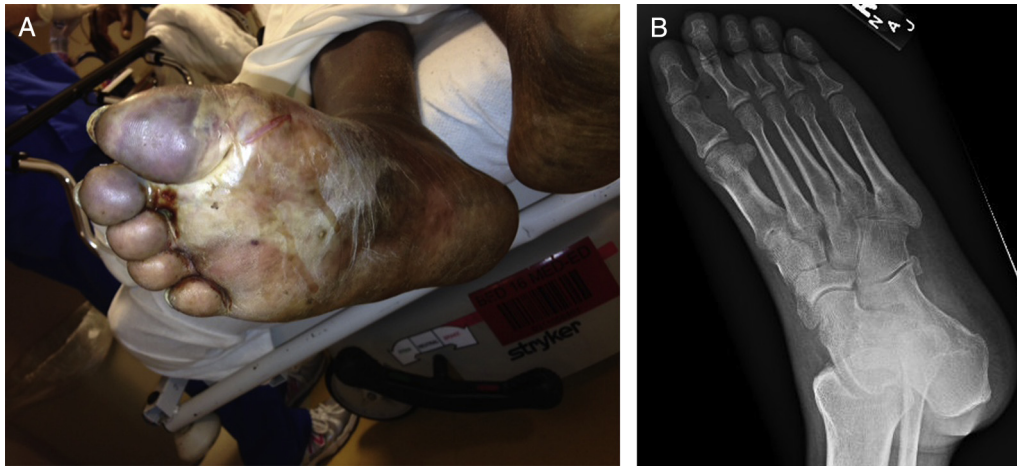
(A) Clinical photograph of a patient with gas gangrene who eventually required a below-the-knee amputation. The procalcitonin value for this patient was only 1.08 ng/mL, less than the median threshold for a foot-sparing amputation. However, because of his medical comorbidities, including end-stage renal disease, insulin-dependent diabetes mellitus, peripheral arterial disease, congestive heart failure, and hepatitis C, this patient was better served with a proximal amputation. (B) Corresponding plain film radiograph displaying a pinpoint area of soft tissue emphysema in the first interspace.
